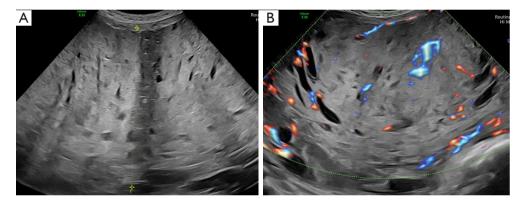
Case 1. (A,B) Ultrasound image at 35 weeks of pregnancy with PMD. The placenta displays diffuse thickening, and there is irregular echogenicity within the placental substance. The affected area is relatively broad, extending over the entrance of the umbilical cord into the placenta. PMD, placental mesenchymal dysplasia.
